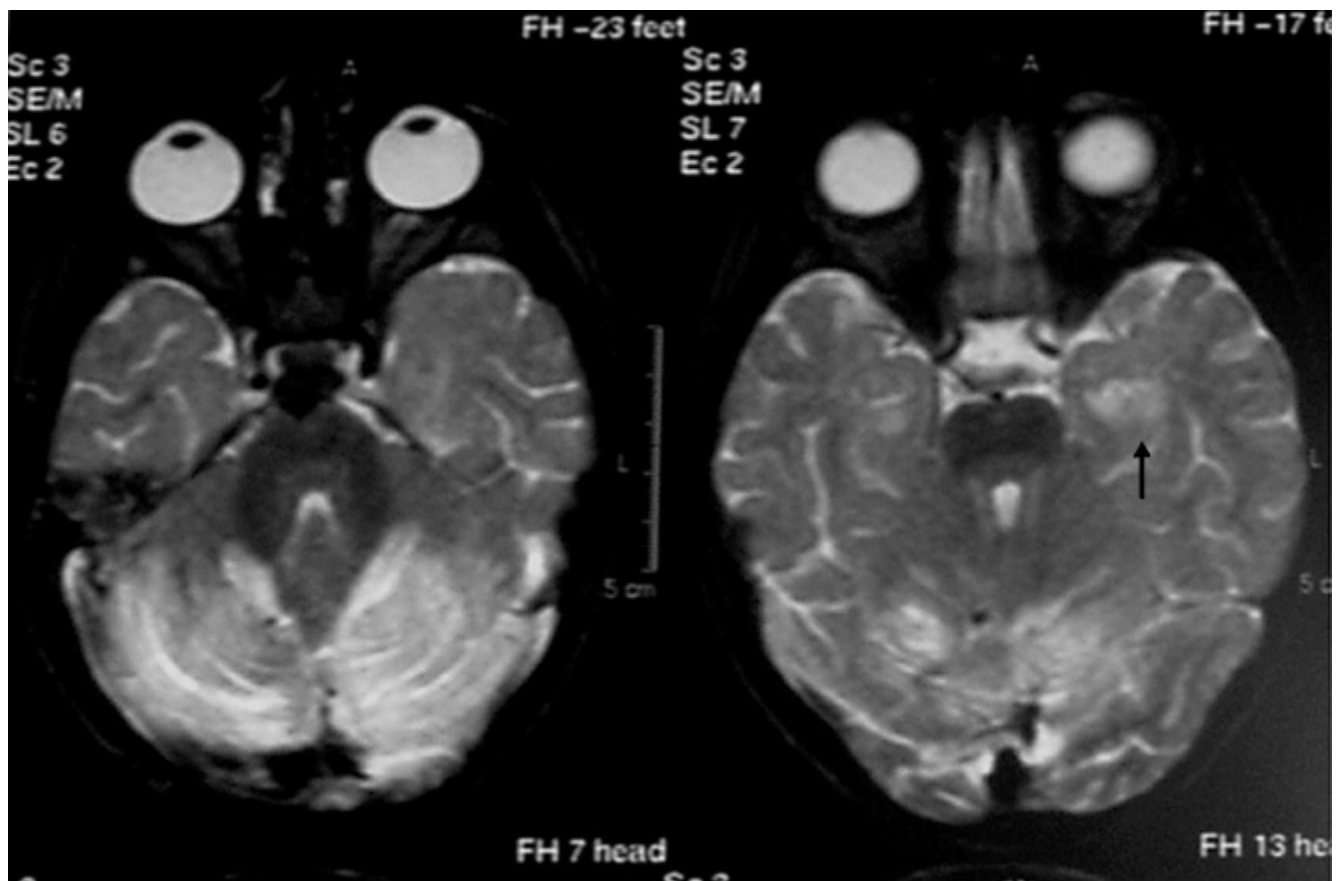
A T₂-weighted magnetic resonance image (MRI) performed on the sixth day in hospital still reveals an abnormal hyperintense signal in the cerebellar hemispheres and hippocampus, bilaterally, but more evident on the left side (arrow).
